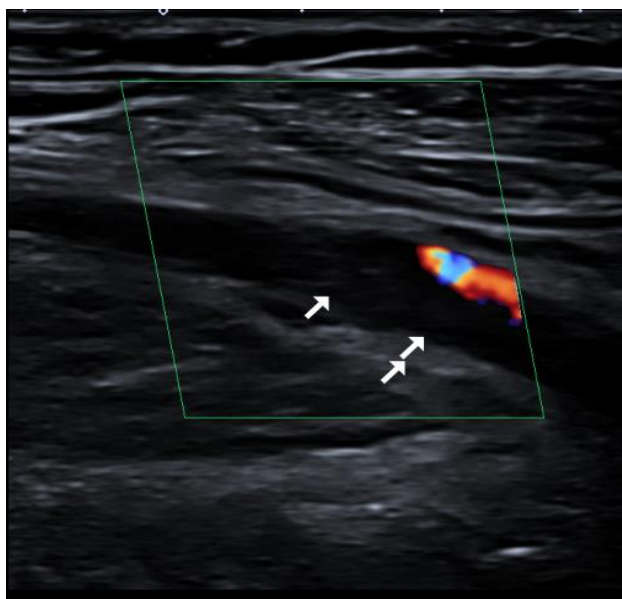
Doppler Scan Demonstrating DVT in Right Popliteal Vein
